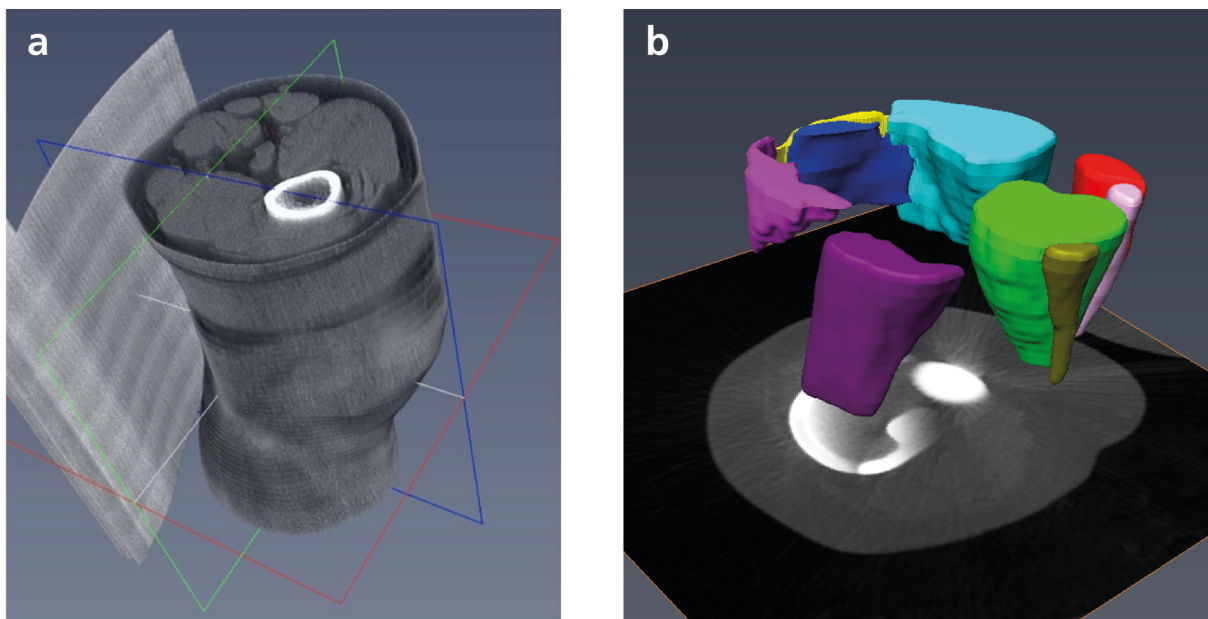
Three-dimensional (3D) reconstruction. 3D visualization of a preoperative CT-dataset of the right leg of one patient used for segmentation (a). 3D image reconstruction of the distal volumes of individual thigh muscles (b). Light purple: vastus lateralis; light blue: vastus medialis; yellow: rectus femoris; dark blue: vastus intermedius; red: sartorius; rose: gracilis; light green: semimembranosus; dark green: semitendinosus; dark purple: biceps femoris.
